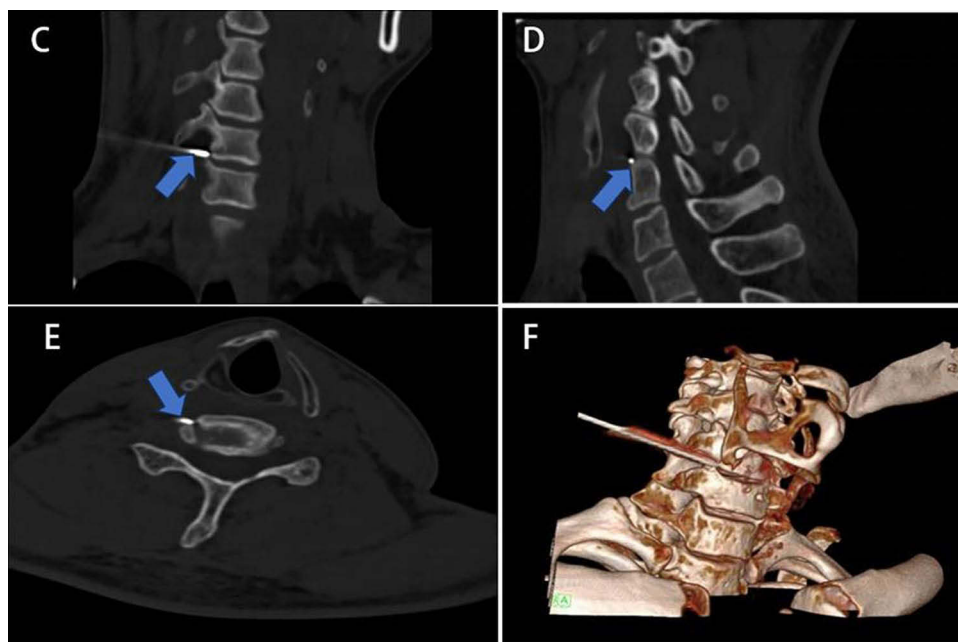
The process of CT-monitored: Arrow shows the puncture tip reaching the edge of the C5-6. ((C) coronal plane (D) sagittal plane (E) transverse plane (F) three-dimensional reconstruction).
